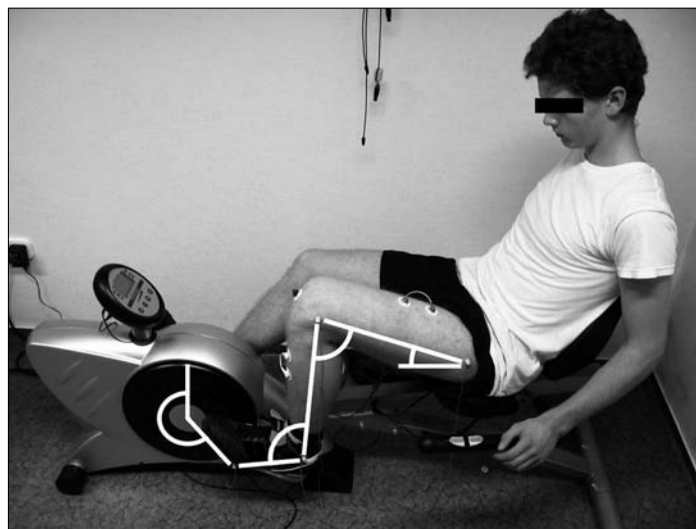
The measurement setup as it was “seen” by the ultrasound-sensors of the motion-analyzer system. The vectors and angles that were defined from the marker positions are also presented
